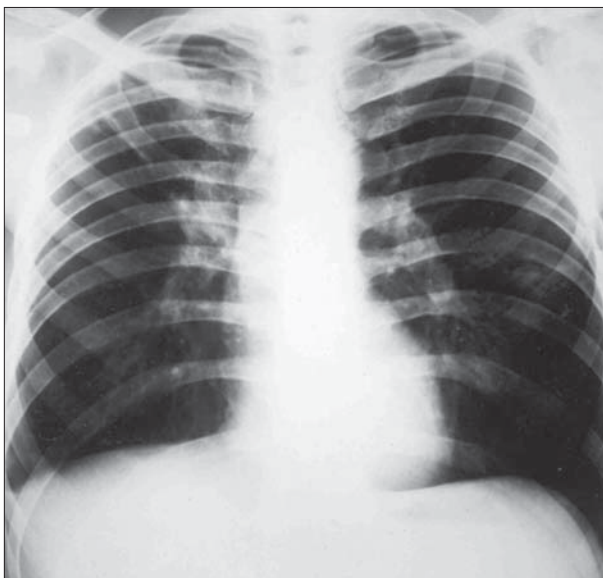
Standard chest radiography one year later: normally sized heart shadow; sequelae tuberculosis in the right upper lobe (second intercostal space) and obtuse right costophrenic sinus due to pleural adhesion
